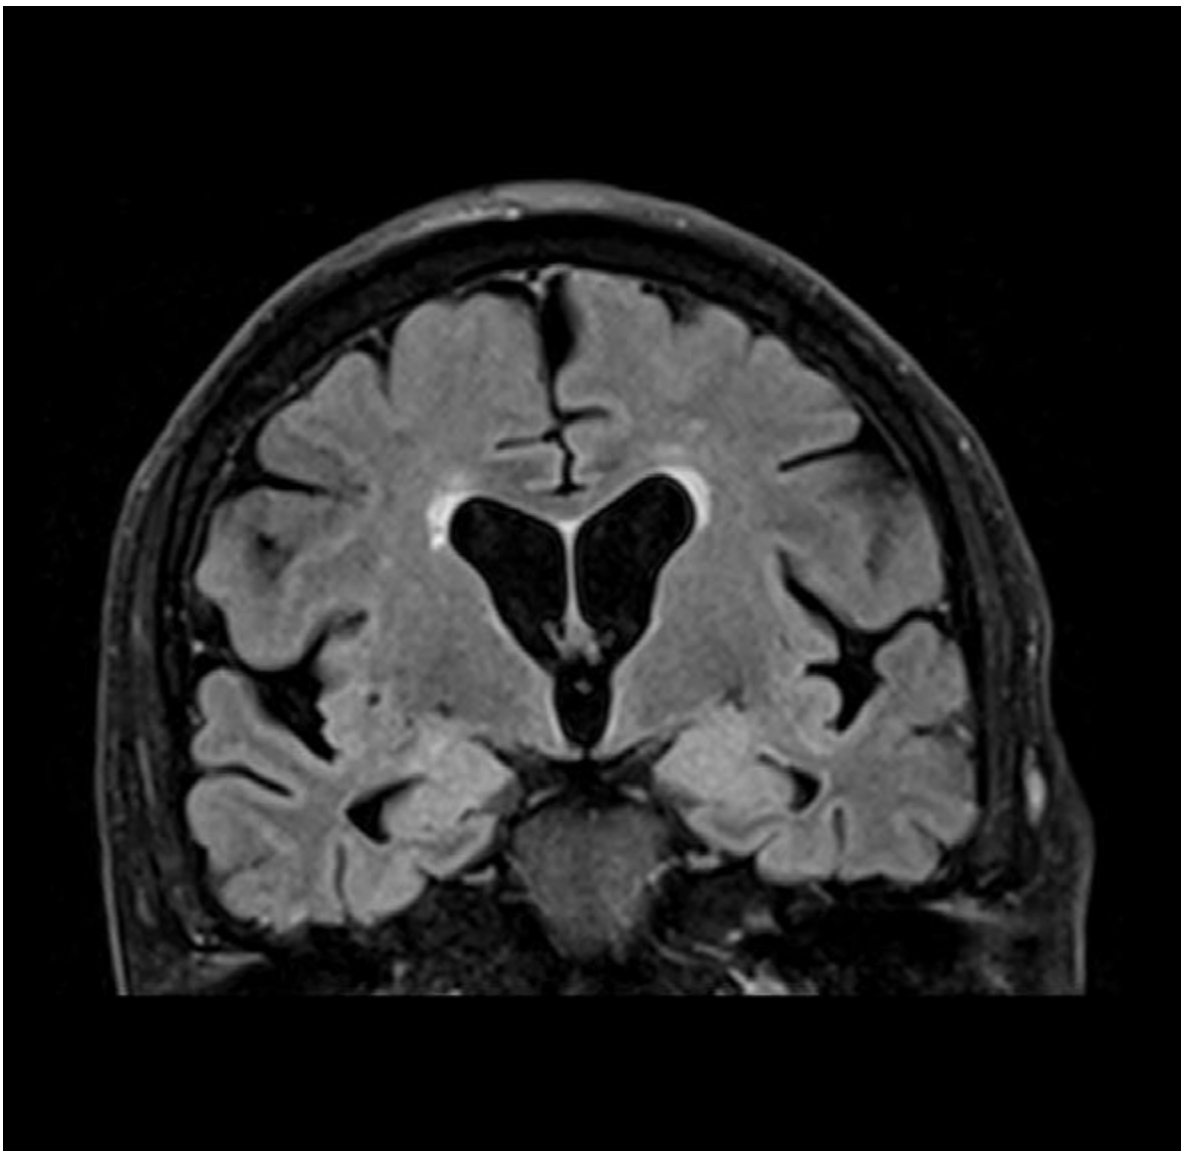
Medial temporal lobe abnormalities in CASPR2 encephalitis. A 71-year-old male patient with CASPR-2 antibodies presented with complex partial seizures, memory deficits and affective disturbance. MRI revealed symmetric FLAIR hyperintensities in the medial temporal lobes. Following extensive immunotherapy with IV steroids, plasma exchange, IV immunoglobulins and rituximab, a mild improvement of symptoms was observed.
